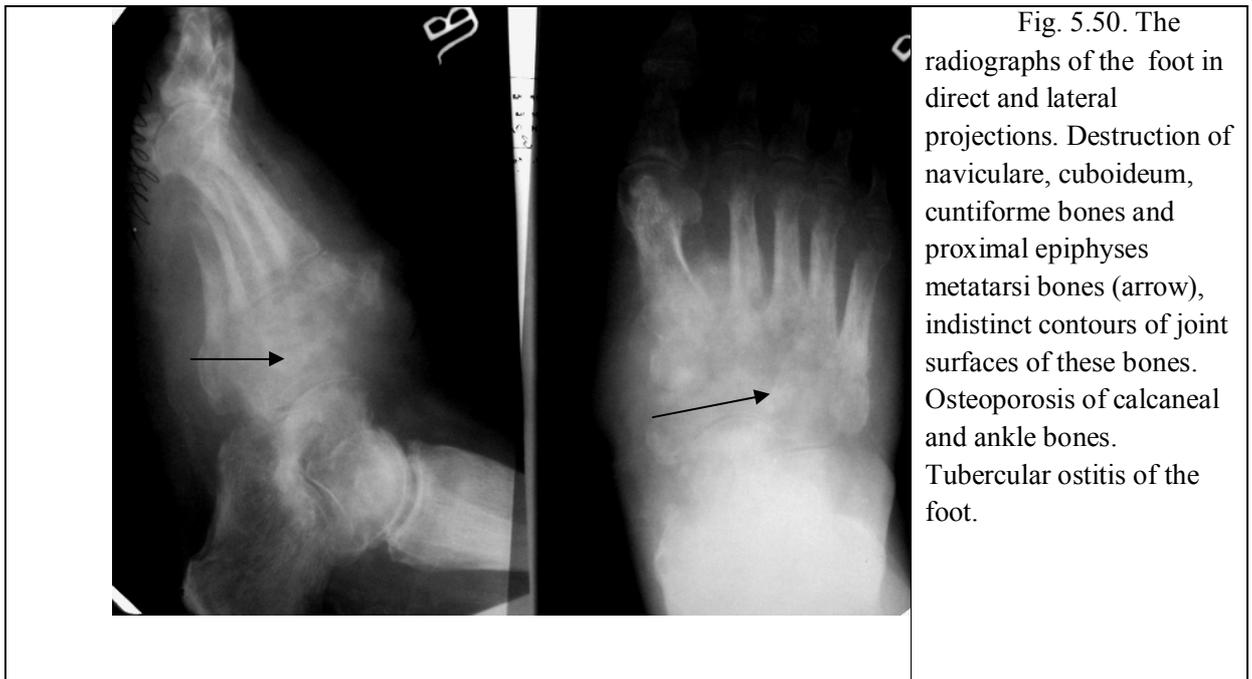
The radiographs of the foot in direct and lateral projections. Destruction of navicular, cuboid, cuneiform bones and proximal epiphyses metatarsi bones (arrow), indistinct contours of joint surfaces of these bones. Osteoporosis of calcaneal and ankle bones. Tubercular osteitis of the foot.
